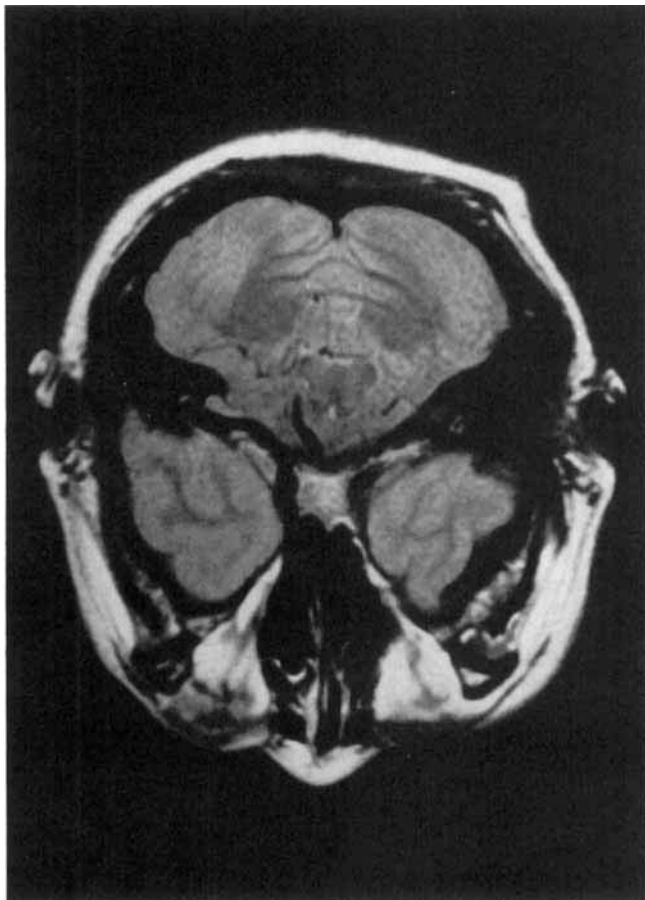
T₁ enhanced MRI of orbital region of the present case. Orbit is filled with fat tissues. Globes are not recognized but there is remnant of eye muscles in the orbit.
